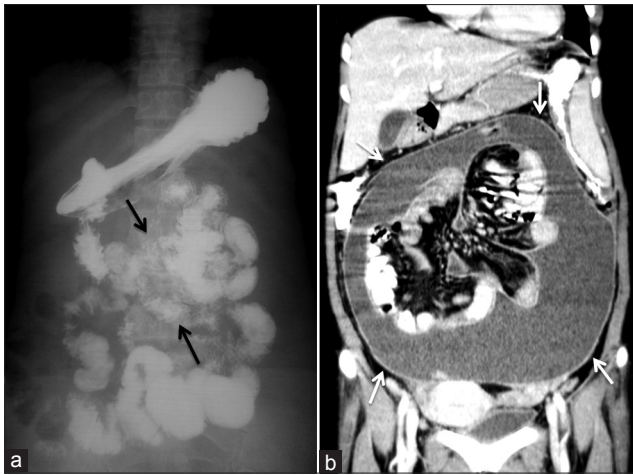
Abdominal cocoon in a 37-year-old male on dialysis. (a) Barium meal follow through spot image showing clustered fixed small bowel loops (arrows). (b) Coronal reformatted computed tomography image showing encapsulating membrane (arrows) with ascites and clustering of small bowel loops
